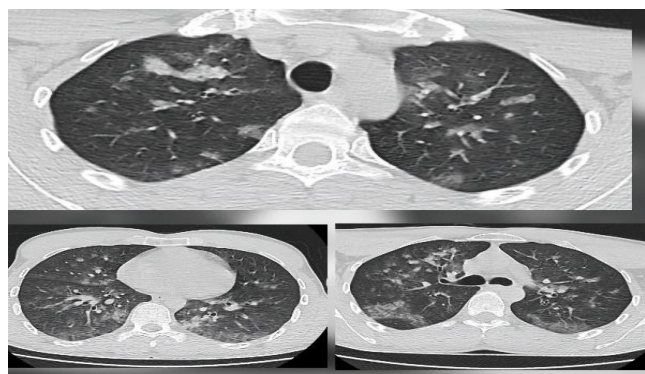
Thoracic computed tomography revealing ground-glass opacities and areas of consolidation
